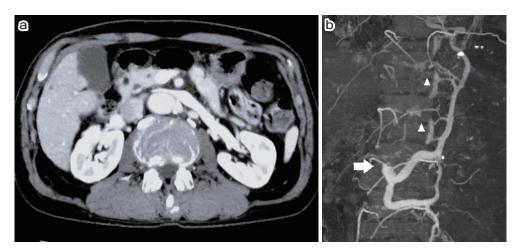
a, b: Computed tomography angiography showing venous outflow obstruction of the left renal vein with a narrowed space between the aorta and superior mesencephalic artery (Fig. 2a), resulting in collateralization of venous circulation involving the hemiazygos vein, superior lumbar vein, lumbar veins, radicular veins, and epidural venous plexus (white arrowheads). The left renal vein is cut at the narrowest part of the stenosis (white arrow).
